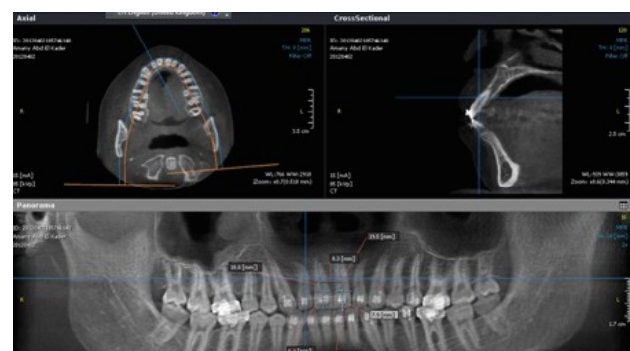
Reformatted panorama of cone beam computed tomography showing linear and angular measurements.
